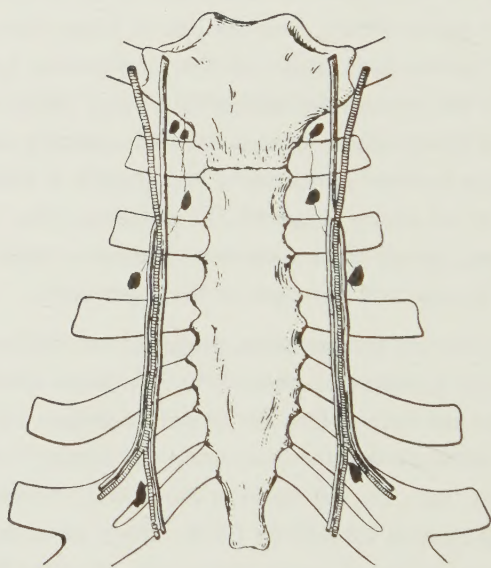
The parasternal lymphatics. From STIBBE (1918).
